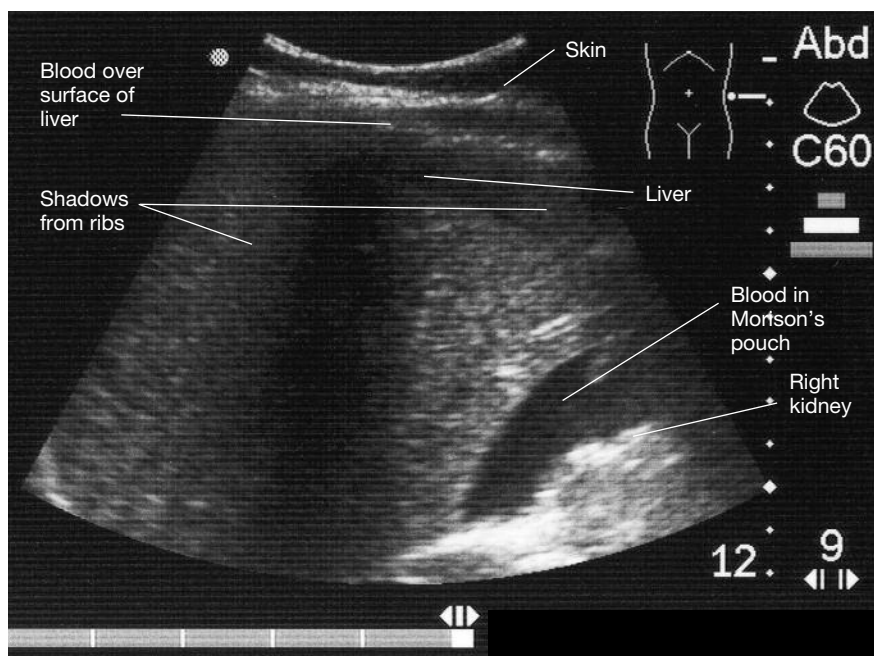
Ultrasound shows a large amount of free blood in the abdominal cavity.
